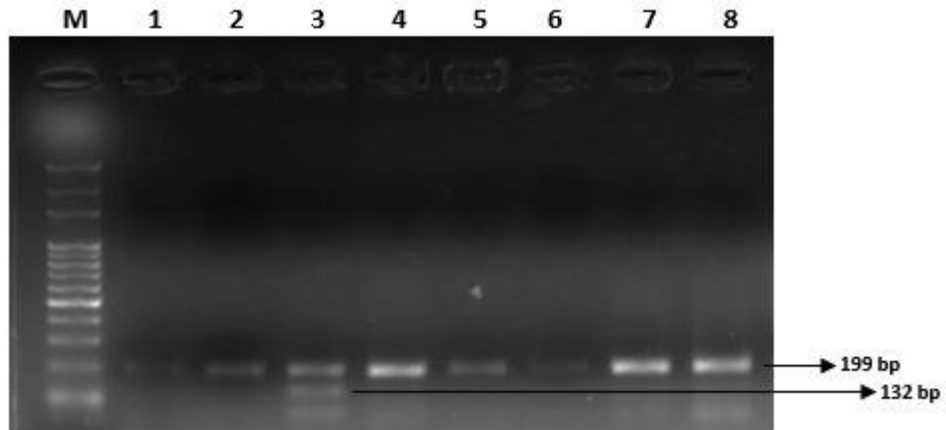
RFLP products for NOS2-1173C/T showing M=100 bp ladder; 1, 2, 4, 5, 6, 7, 8 = CC (normal genotype); 3 = CT (variant genotype).
